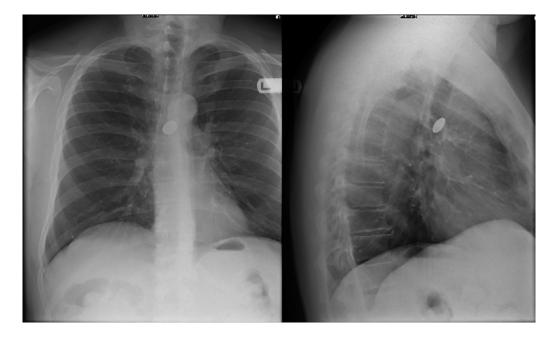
This figure depicts the anterior-posterior, posterior-anterior, lateral chest X-ray:  $2 \times 2 \times 0.2$  cm well-circumscribed hyperdense structure against the posterior surface of the distal trachea and projecting over the region of the carina. Most likely representing an aspirated foreign metallic object. No signs of lung collapse.
